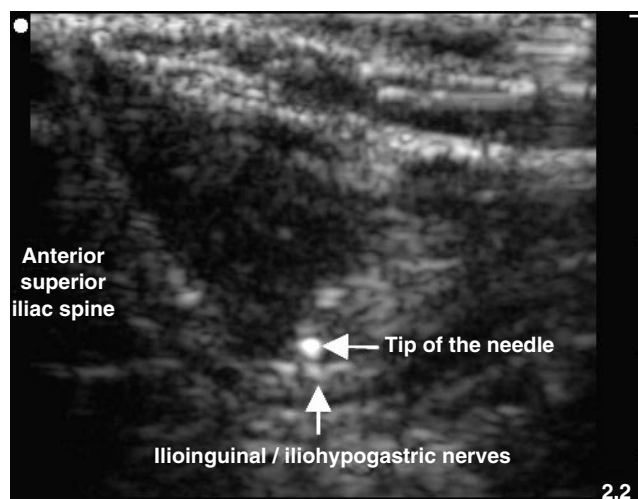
Ultrasonographic view of the relationship of the tip of the needle to the ilioinguinal/iliohypogastric nerves.
